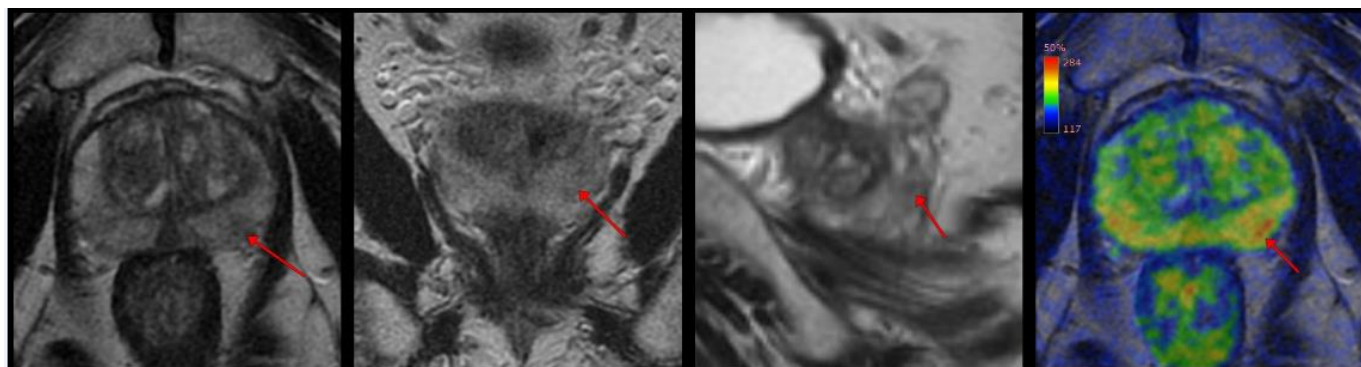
MRI of the posterior peripheral zone PCa
